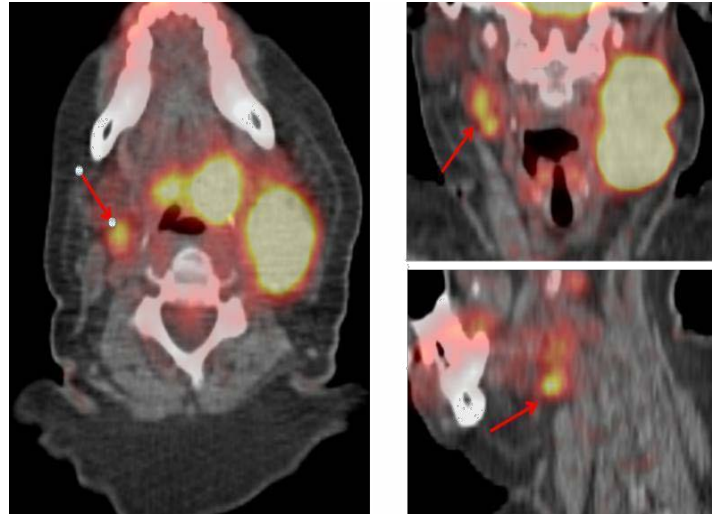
Representative axial, coronal, and sagittal staging PET/CT images revealing predominantly left sided disease, although a small hypermetabolic right level II node was seen (red arrows).
